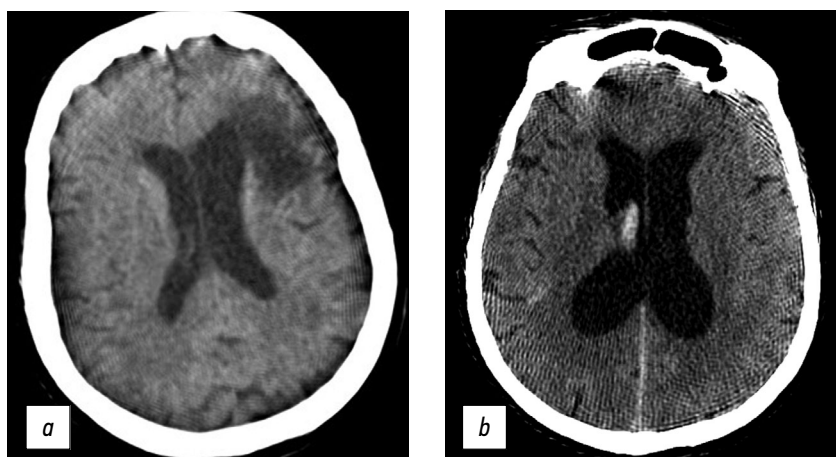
Axial computed tomographic images of the brain: (a) reconstruction of a 3-mm low-density area at the anterior horn of the left lateral ventricle, in the periventricular, subcortical direction (CT image of subacute cerebrovascular accident of the left middle cerebral artery), and (b) a 1-mm site of subarachnoid hemorrhage with blood breakthrough into the ventricular system (vicarious hydrocephalus).
